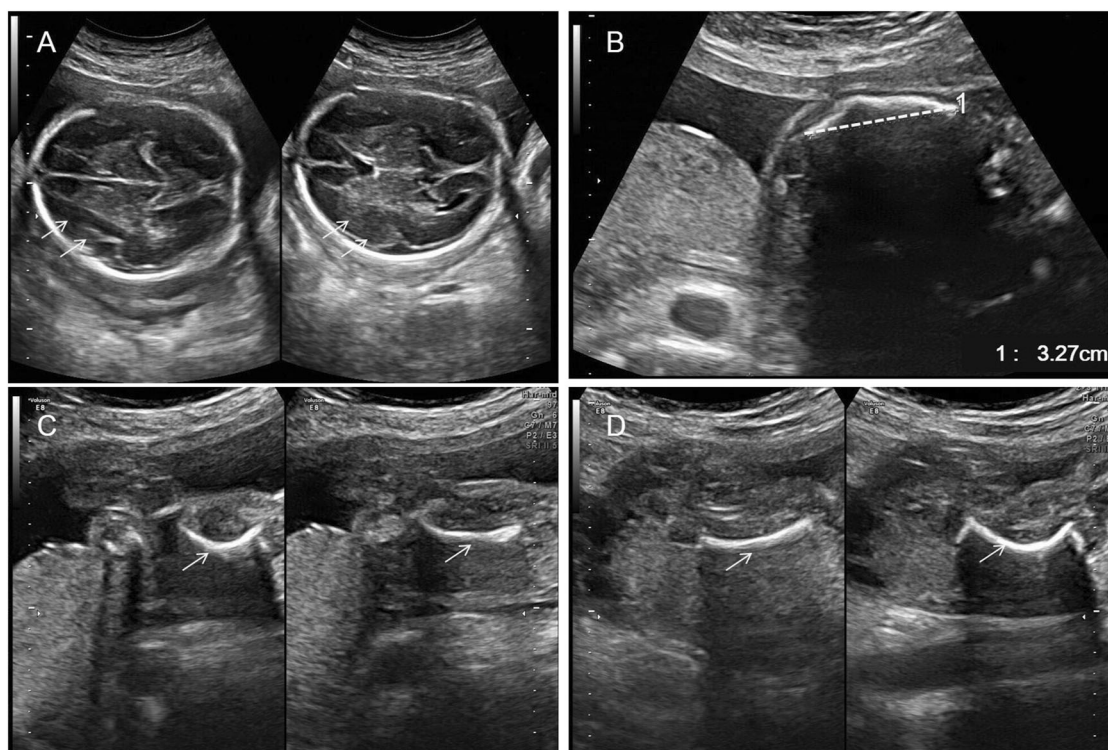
Real-time graphs of B-mode ultrasonography of the fetus at 26 weeks of gestation. A The yellow arrow indicates the skull region. Echo in this region is reduced, which suggests that the fetal skull is
